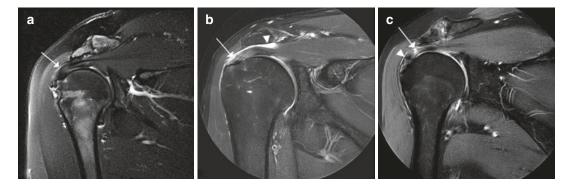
MRI signal changes in asymptomatic patients after cuff repair. Coronal oblique T2-weighted fat suppressed MRI images of the shoulder post supraspinatus tendon repair in three different patients. (a) Repaired tendon demonstrates dark signal without defect (arrow) compatible with Sugaya grade I. (b) Repaired tendon
